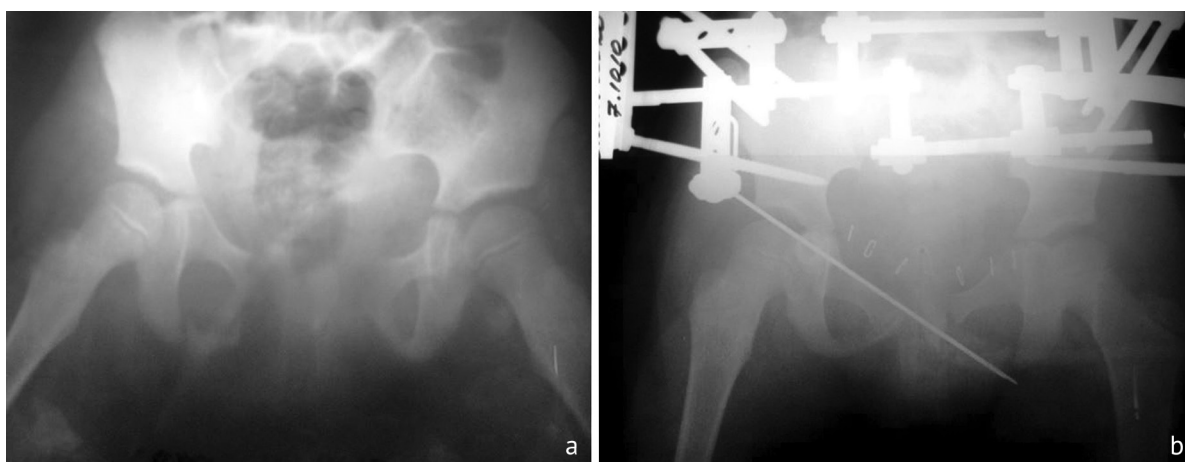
Radiographs of the pelvis: *a* upon admission (direct view, fracture of the pubic and ischial bones with rupture of the pubic and sacroiliac joints); *b* condition after the intervention (urethral reconstruction, pelvic osteosynthesis with a wire-and-half-pin EFD)
